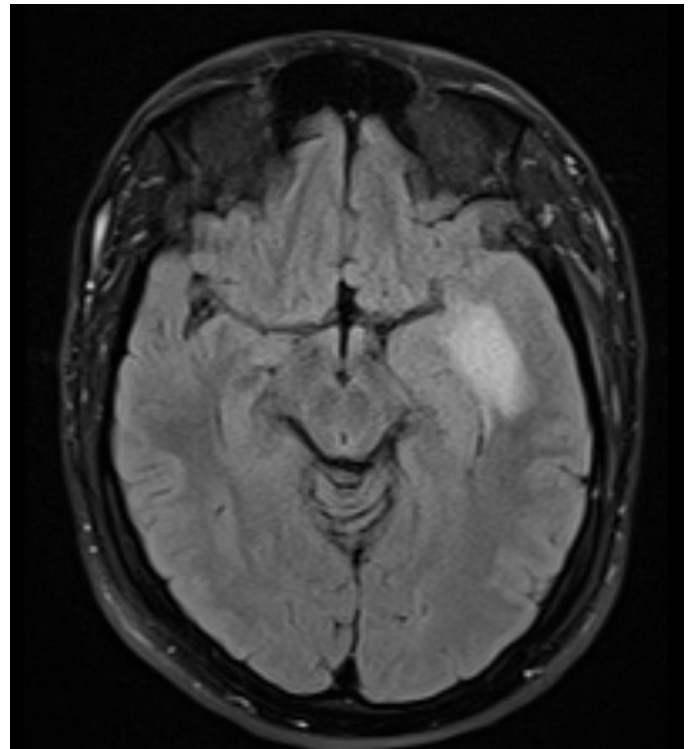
MRI shows a vasogenic edema, with mass involvement in the dura, temporal muscle, and bone.
